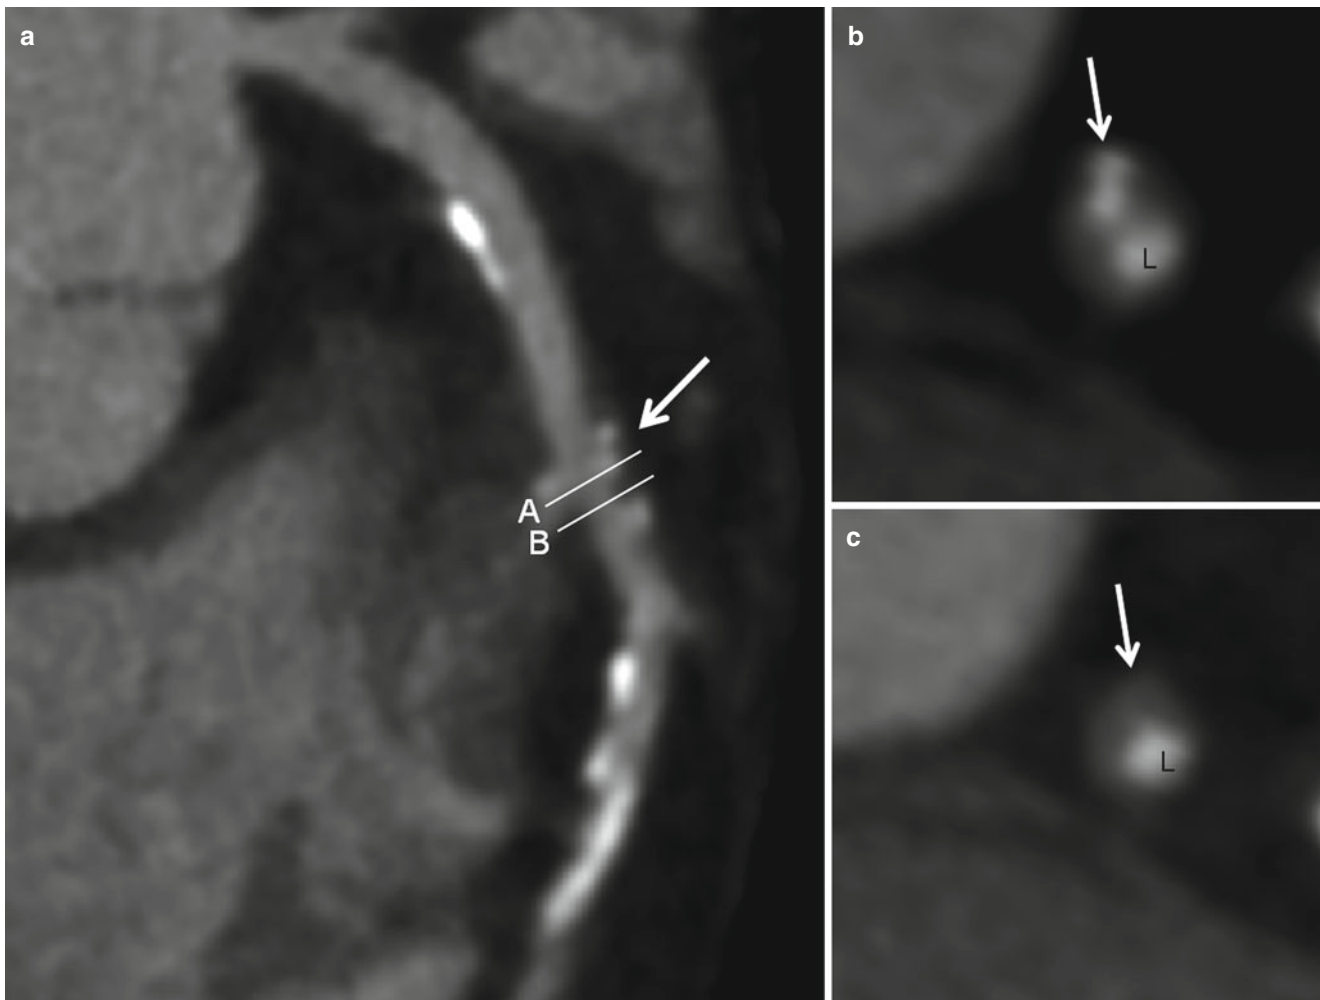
Mixed plaque. (a) Curved multiplanar reformatted (MPR) image of coronary computed tomographic angiography (CCTA) demonstrates multiple calcified plaques and mixed plaque (*arrow*) in the proximal and middle segments of the left anterior descending artery with significant stenosis caused by mixed plaque. (b) Cross-sectional
